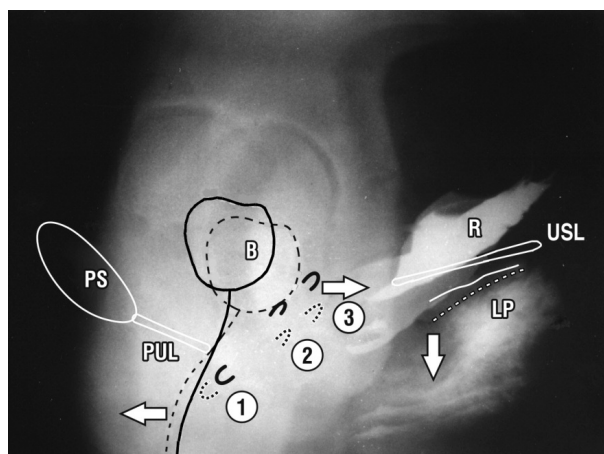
Same patient and labelling as figure 2. Straining x-ray superimposed on resting. Reflex muscle movements during coughing and straining. Note how the directional movements, forwards (mid urethra '1'), backwards (bladder neck '2' and bladder base '3') all pull against PUL (pubourethral ligaments) and how the downward movements appear to be activated by downward angulation of levator plate, which pulls against (USL) uterosacral ligaments.
